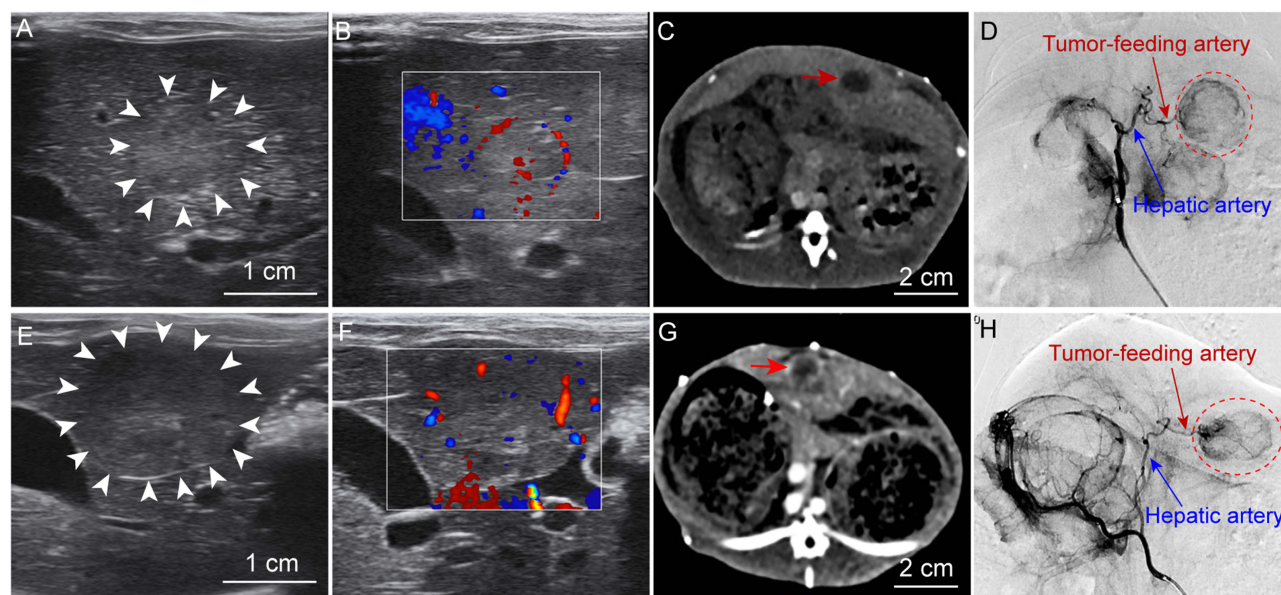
Imaging features of the two groups. (A–D) Puncture implantation under LA and (E–H) open laparotomy implantation under GA, imaged two weeks post-modelling. (A and E) Ultrasonography shows solitary VX2 tumors with homogeneous, slightly hypoechoic echogenicity compared to the surrounding liver parenchyma and well-defined margins (white arrows indicate tumor borders), mostly presenting as round or oval shapes. (B and F) Color Doppler reveals relatively prominent blood flow signals surrounding and within the tumors. (C and G) CE-CT demonstrates oval-shaped tumors within the liver parenchyma with clear boundaries (red arrows). (D and H) DSA shows hypervascular tumors, with clear visualization of the hepatic artery and tumor-feeding arteries (the VX2 tumor is highlighted within the red dashed circle).
